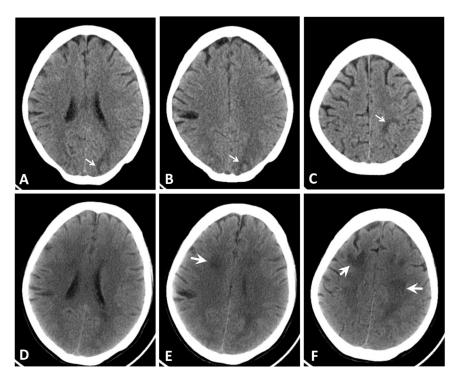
On the fifth day after admission, cranial CT imaging revealed a left occipito-parietal infarction following the initial thunderclap headache. By the sixth day, the infarct size had expanded, as observed in the follow-up images (E, D, and F).
